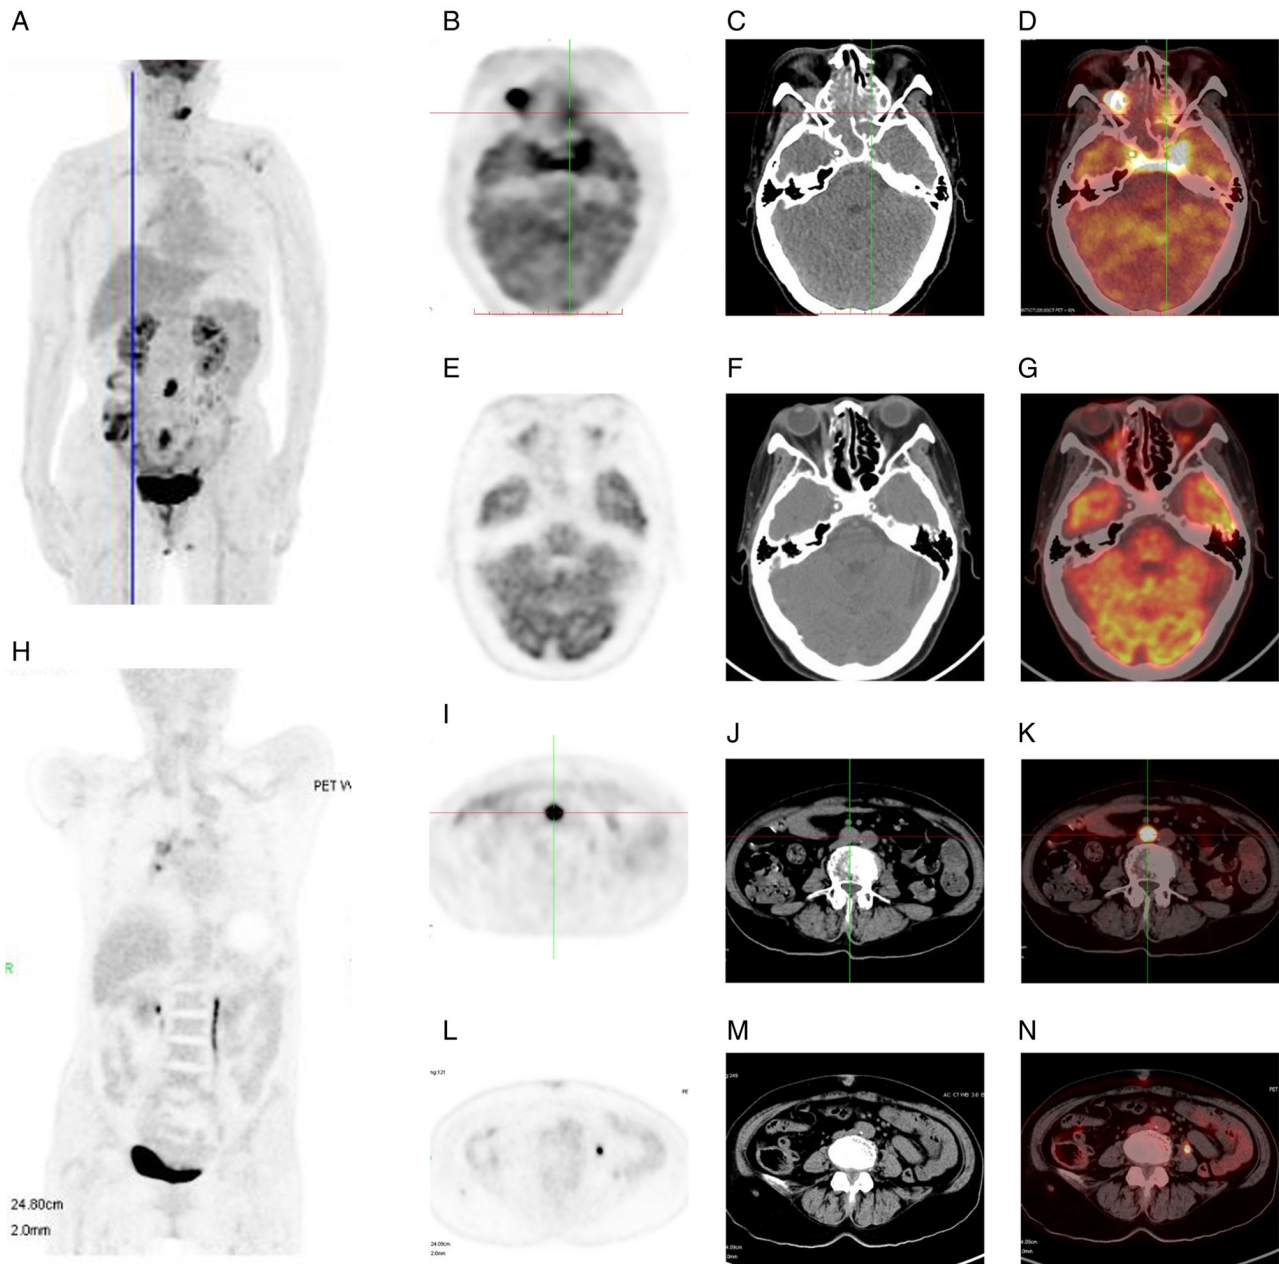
$^{18}\text{F}$ -FDG PET/CT images of the patient with intravascular large B-cell lymphoma. (A) Maximum intensity projection images at baseline. (B) Baseline PET image of the CS, orbit and sinuses. (C) Baseline CT scan image corresponding to image B. (D) Baseline PET/CT fusion image of the CS, orbit and sinuses demonstrating intense FDG uptake in the bilateral CSs and right orbital mass. (E) Follow-up PET image after treatment corresponding to image B. (F) Follow-up CT image after treatment corresponding to image C. (G) Follow-up PET/CT fusion image after treatment corresponding to image D showing complete metabolic resolution of the right orbital lesion and absence of abnormal FDG uptake in the orbit or CSs. (H) Maximum intensity projection images after eight cycles of R-CHOP regimen. (I) Baseline PET image of the abdomen. (J) Baseline CT scan image of the abdomen. (K) Baseline PET/CT fusion image of the abdomen revealing marked FDG uptake in the lymph nodes surrounding the abdominal aorta. (L) Follow-up PET image after treatment corresponding to image I. (M) Follow-up CT image after treatment corresponding to image J. (N) Follow-up PET/CT fusion image after treatment corresponding to image D demonstrating no enlarged lymph nodes or high radiotracer uptake in the abdominal cavity. (B-N) Axial view. CS, cavernous sinus; PET-CT, positron emission tomography-computed tomography; FDG, fluorodeoxyglucose; R-CHOP, rituximab, cyclophosphamide, doxorubicin, vincristine and prednisolone.
